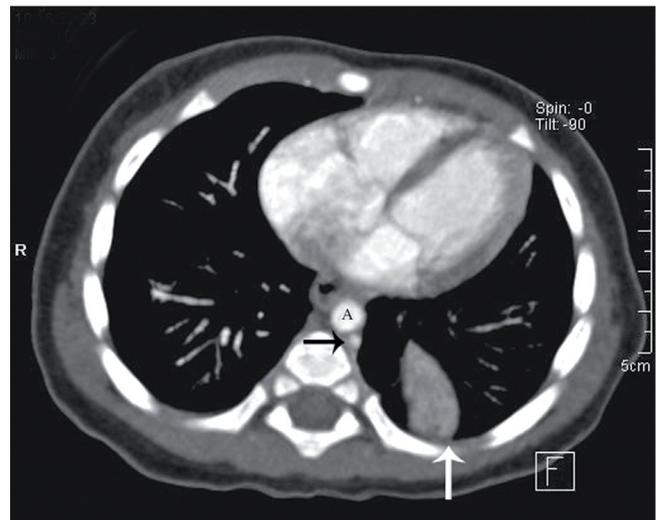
Axial CT scan through the lower chest, demonstrating the oval, solid mass in the left lower lobe, posteriorly (white arrow). Note also the prominent hemi-azygous vein (black arrow), running dorsal to the descending thoracic aorta (A).
